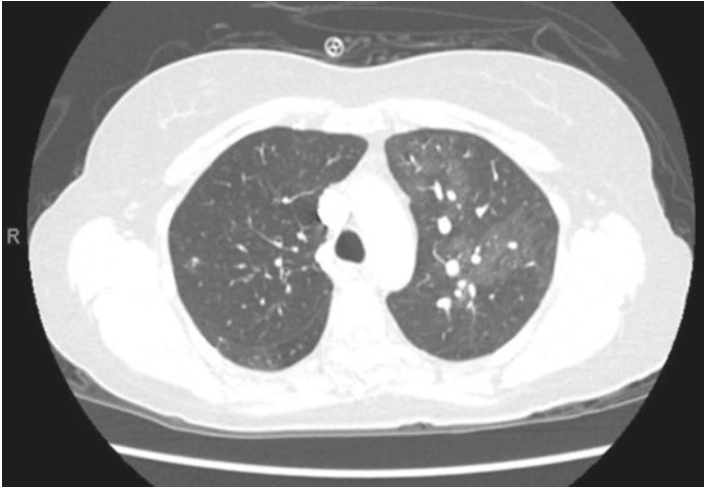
Computed tomography angiography (pulmonary window) showing mosaic perfusion pattern more evident in the left lung, with areas of hypo- and hyperperfusion
